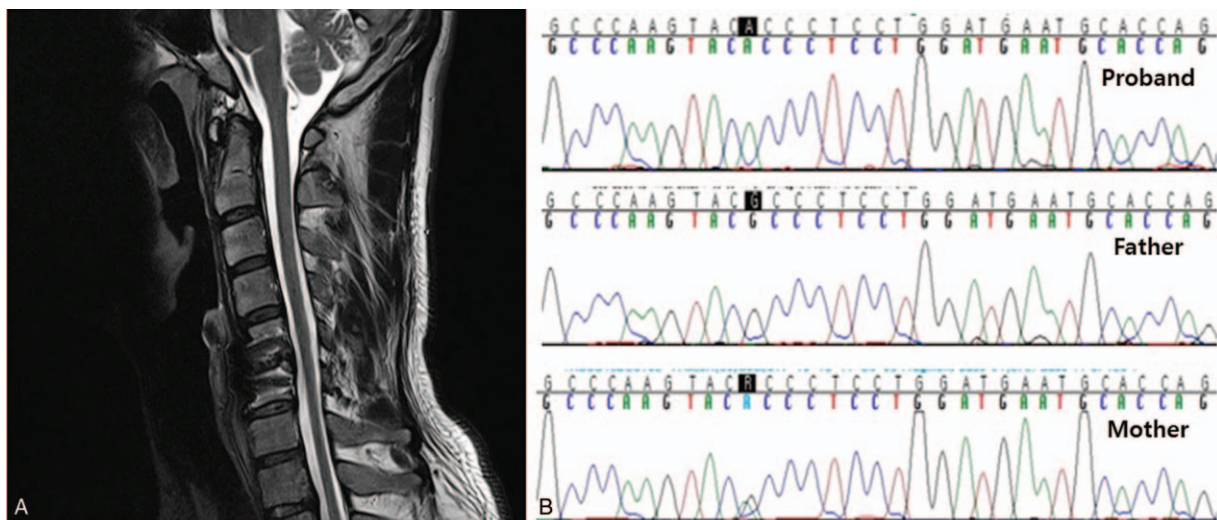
The cervical spine magnetic resonance imaging of the patient shows mild cord atrophy (A). The sanger sequencing of the proband and his family showed a known pathogenic mutation (c.1876G>A, p.A626T) in ABCD1 gene (B). ABCD1=ATP-binding cassette, subfamily D, member 1.
